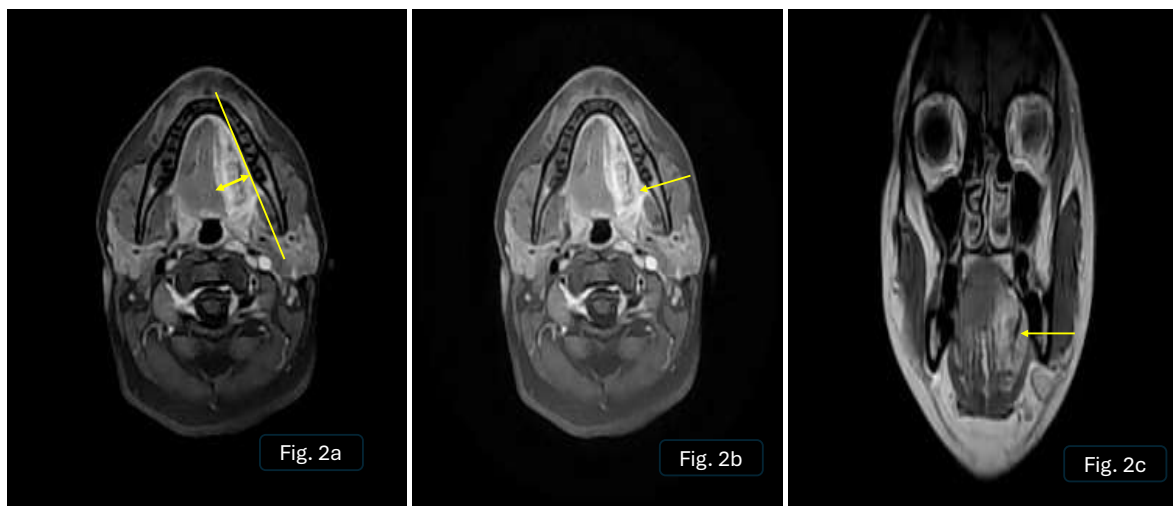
A 31-year-old female with oral ulcer on left lateral aspect of tongue underwent Mult sequential CE-MRI face and neck
